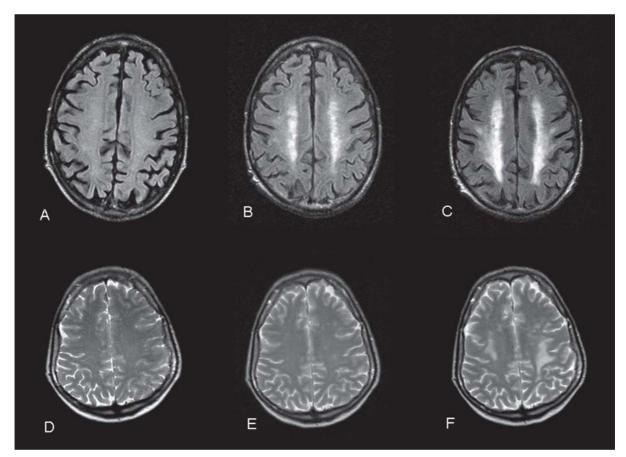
Case 2 (A–C) (radiation dose 30 Gy/10 fr and TMZ). Axial FLAIR magnetic resonance image: A before WBRT shows slight bilateral hyperintensity of semioval centres (grade I); B nine months after WBRT shows serious bilateral symmetrical hyperintensity of both semioval centre (grade II); C 15 months after treatment shows increased bilateral symmetrical hyperintensity of semioval centres (grade III). Case 5 (D–F) (radiation dose 20 Gy/5 fr and TMZ). Axial T2-weighted fast spinecho (FSE) MRI: D previous WBRT does not show abnormalities; E 10 months after WBRT shows incipient bilateral asymmetrical hyperintensity of both semioval centres (grade I); F 13 months after treatment shows worsening with bilateral and increased asymmetrical hyperintensity of semioval centres (grade II)
